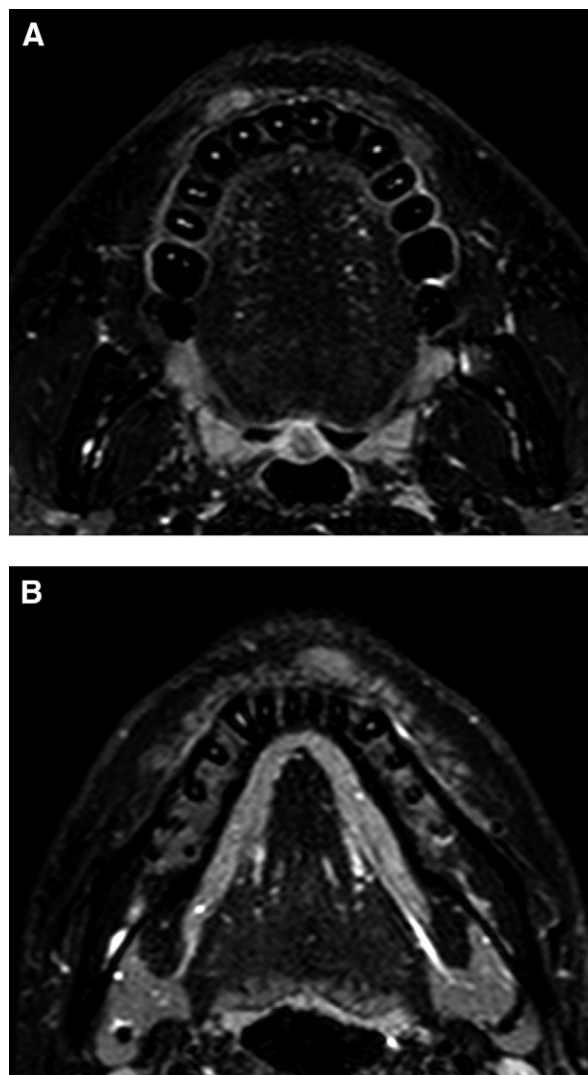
Axial contrast-enhanced T1-weighted magnetic resonance images revealed well circumscribed moderately hyperintensive masses of the (A) upper and (B) lower lips.
